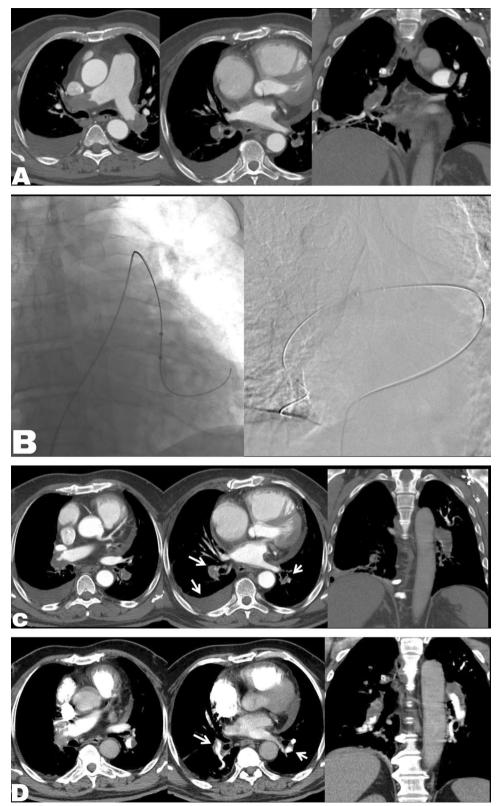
60-year-old patient, A An axial and coronal contrast CT chest PE study shows bilateral massive PE; the patient was hemodynamically unstable; IV thrombolysis and anticoagulation are contraindicated. B Angiojet catheter PE is noted, and PMT was done. C, D pre- and post-procedure CT chest PE study axial and coronal images show recanalization of occluded arteries
